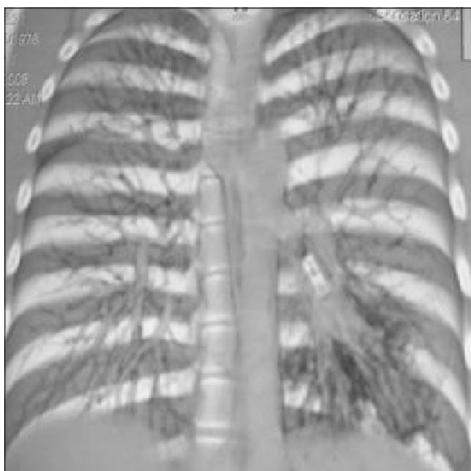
Computed tomography thorax shows atelectasis of the left lower lobe
